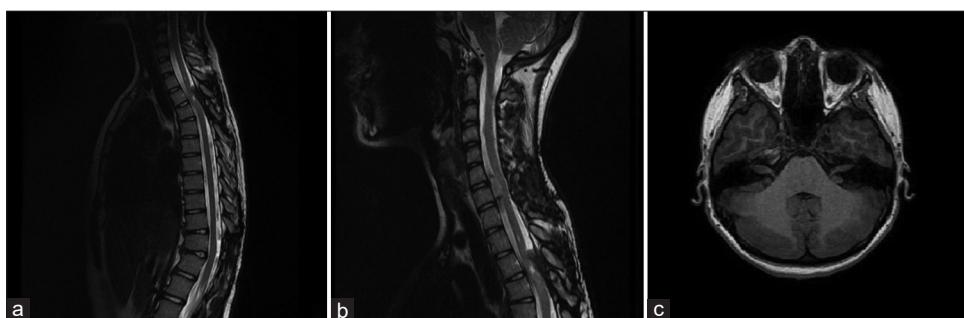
MRI scan performed after 3-year follow-up of Patient No. 2: (a) Sagittal T2-weighted thoracic MRI shows multiple small meningiomas at the Th2, Th5, Th8, Th9, Th11, Th12/L1 levels, and a tumor at the Th3-Th4 level sized $17 \times 7 \times 27$ mm causing spinal cord compression. (b) Sagittal T2-weighted cervical MRI presents tumors at the C2–3 and C6–7 levels with spinal cord compression. (c) Axial T2-weighted cervical MRI shows bilateral vestibular schwannomas.
